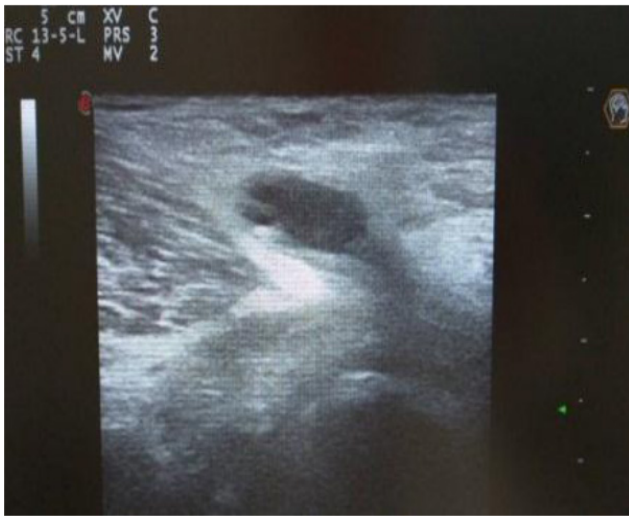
Regression of cyst – ultrasound.
